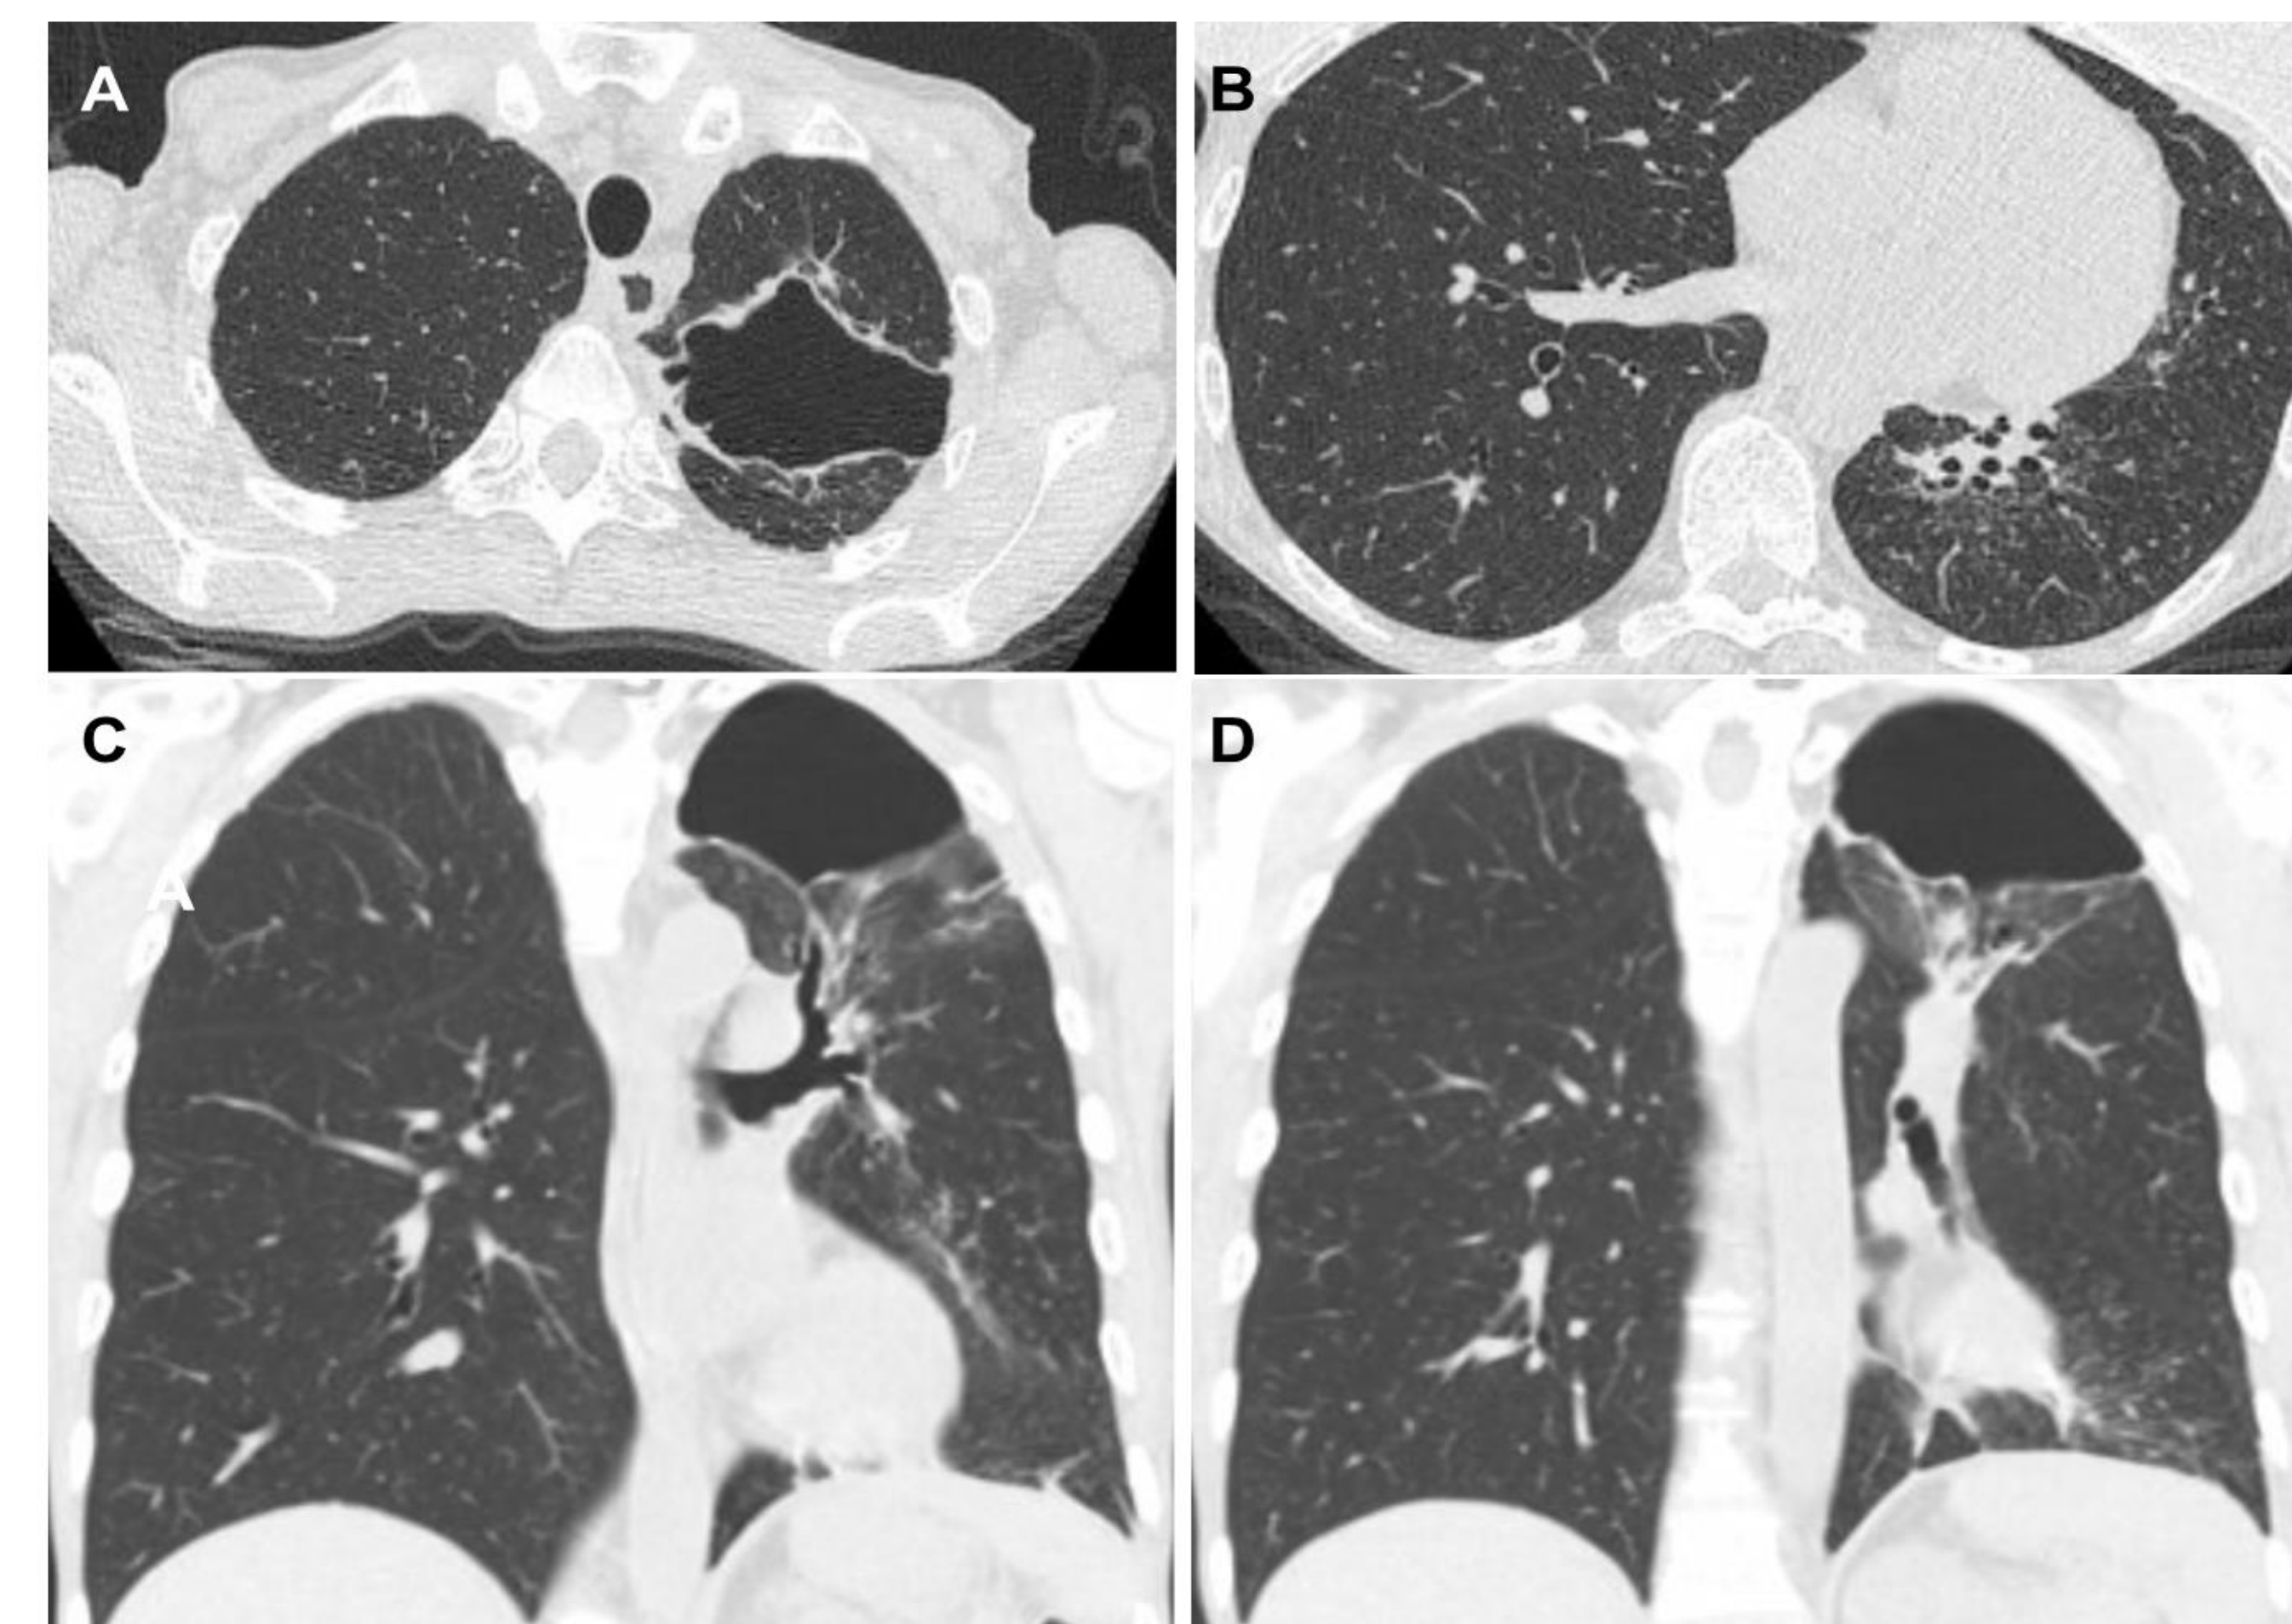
Interval CT chest 4 months later showing persistent left apical cavity, development of apical fibrosis, volume loss, mediastinal shift and left lower lobe scarring.
